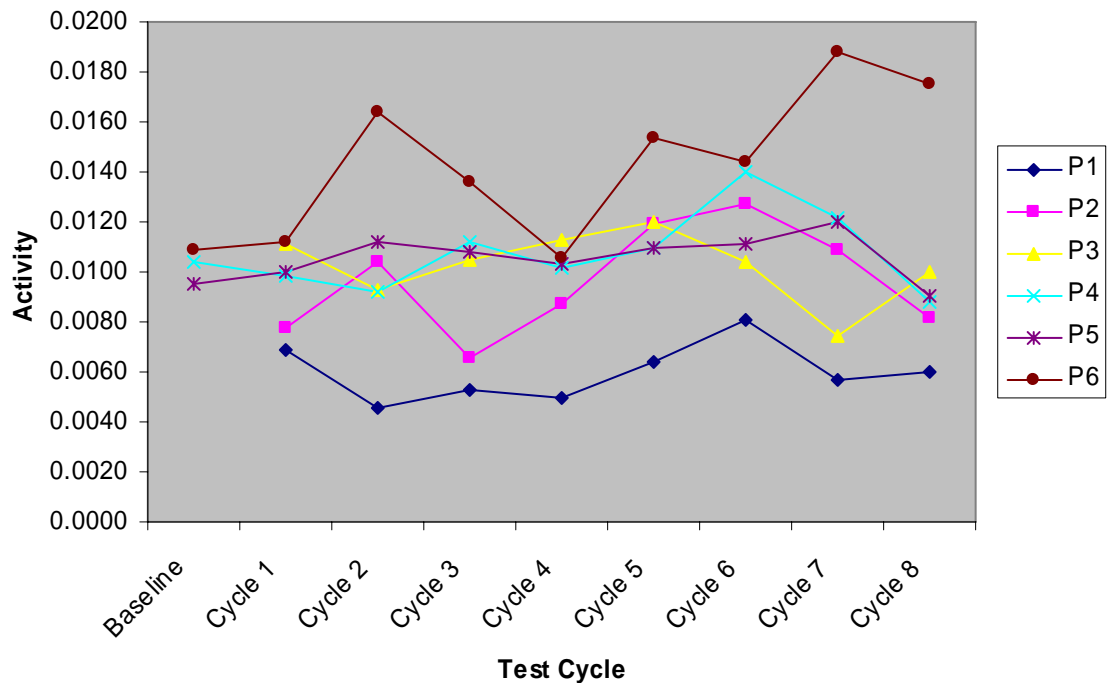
Data showing the activity for each participant during testing. Activity reflects the average of the Doppler microwave signal during the four test periods for each cycle.
